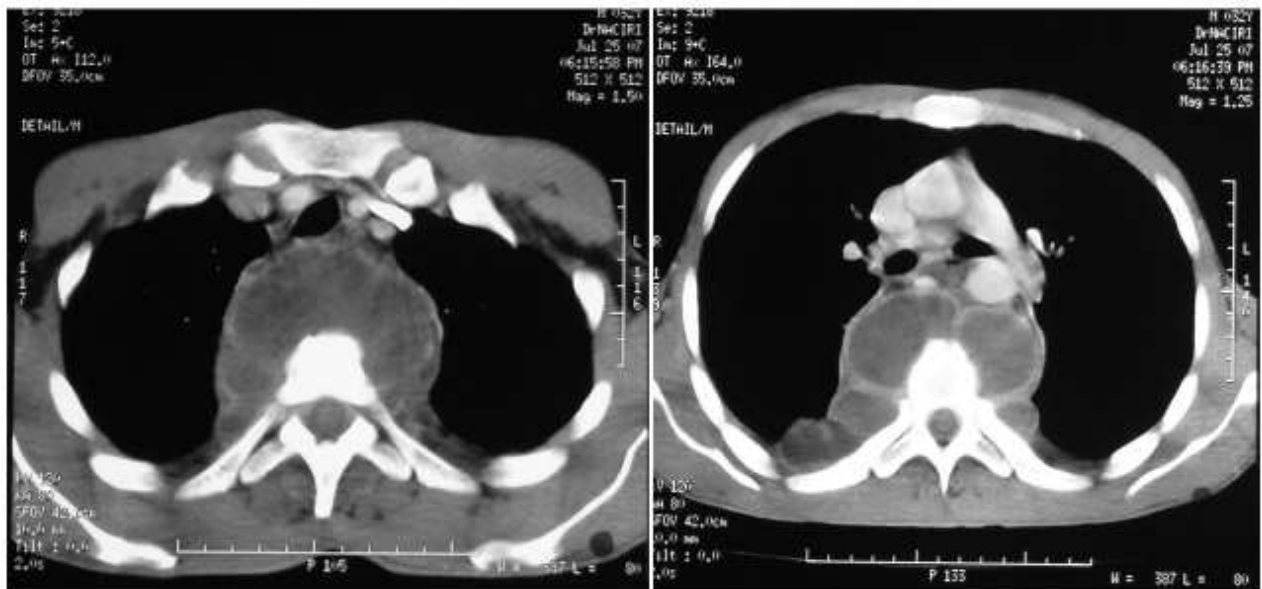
CT Scan : para- vertebral abscess.
